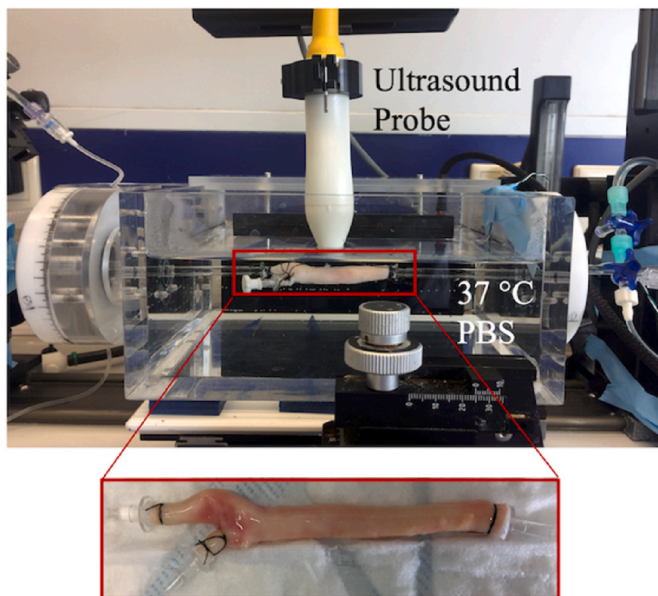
The custom built inflation setup to test atherosclerotic human carotid arteries, and the 21 MHz ultrasound probe.
